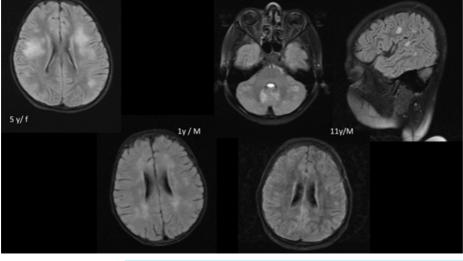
MRI findings of the three children
